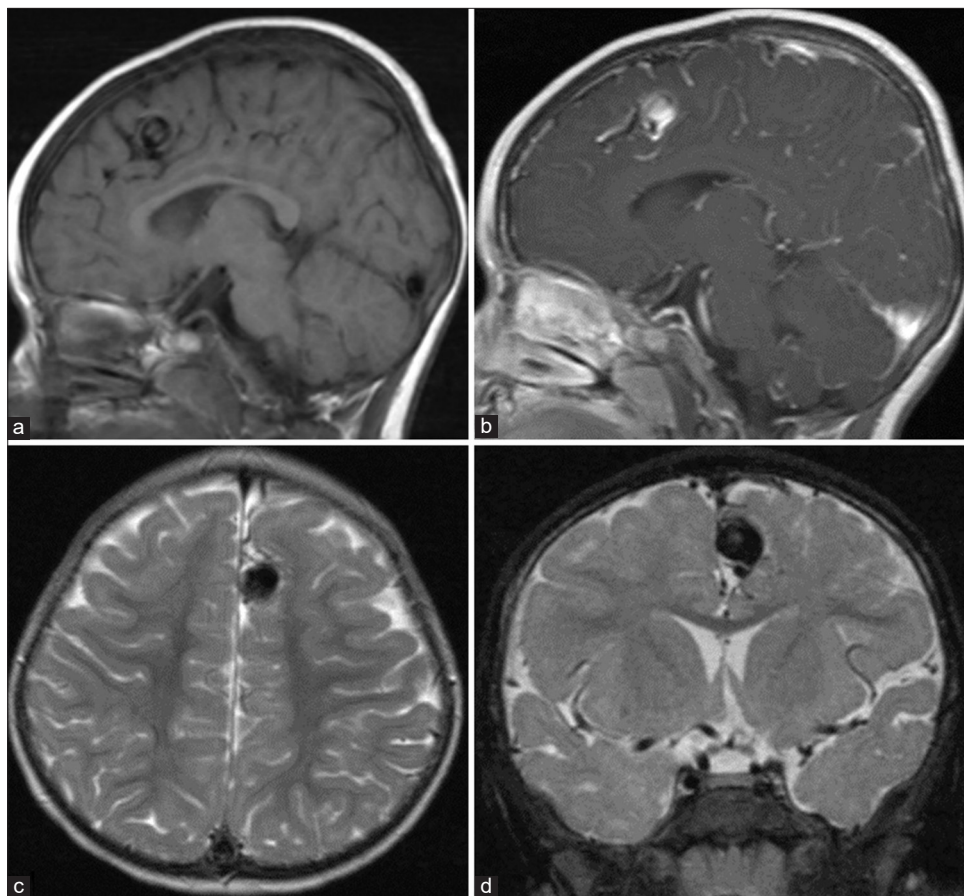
Magnetic resonance imaging (MRI) of the brain obtained 1 month after symptom onset. Sagittal T1-weighted MRI (a) with and (b) without contrast show heterogeneous signal intensity with eccentrically rim enhancing lesion, probably representing a laminated appearance of partially thrombosed aneurysm. (c) Axial and (d) coronal T2-weighted MRI reveals heterogeneous signal intensity in a large aneurysm surrounded by edema of the left superior frontal gyrus.
